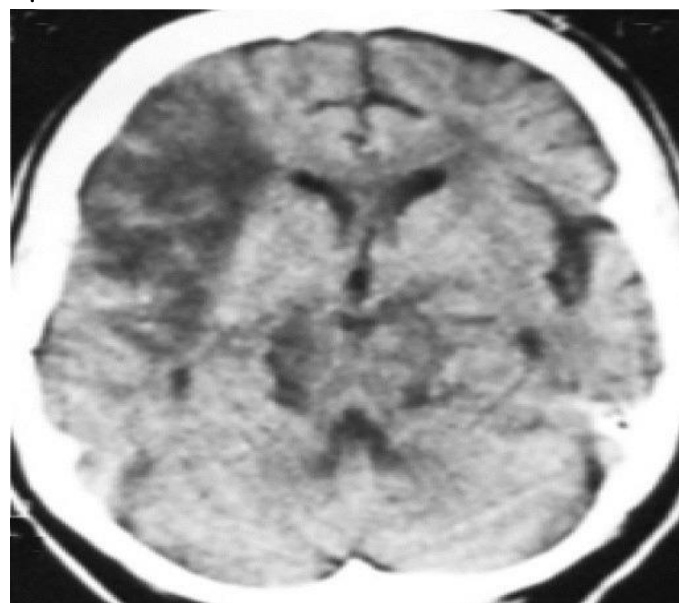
CT scan image of the brain showing infarct-like lesion in the right frontal-parietal lobe in a patient with HIV [30].
